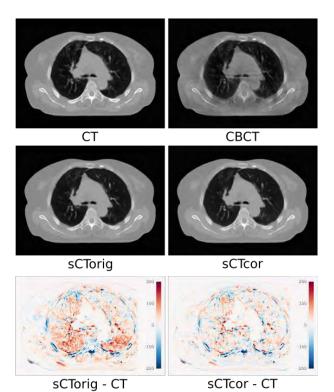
Overview of reference CT, CBCT, original sCT (sCTorig), corrected
